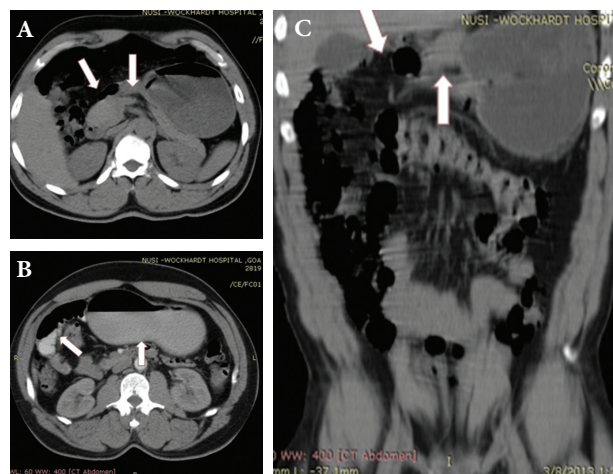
(A,B,C) Horizontal and coronal sections of computed tomography scan showing normal but overdistended stomach with retained contrast with abrupt cutoff just proximal to pylorus. Pylorus and duodenum are of normal calibre without any lesion or thickening (arrows image A and C) with some contrast emptying into the duodenum indicating partial obstruction (arrows image B)
